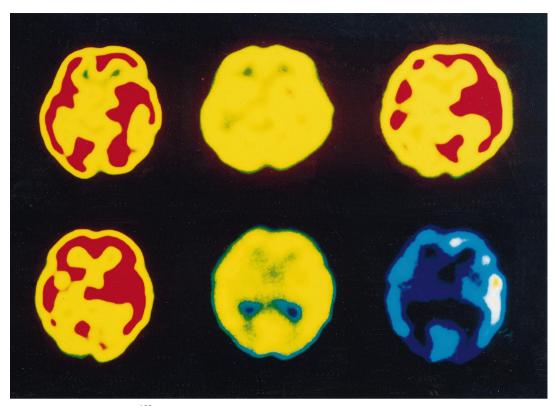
Sequential CBF images with ¹²³I-IMP SPECT in patients with a good outcome (*top row*) and with a poor outcome (*bottom row*). (*Top row, left to right*: day 1, day 13, day 28; *bottom row, left to right*: day 1, day 30.)
